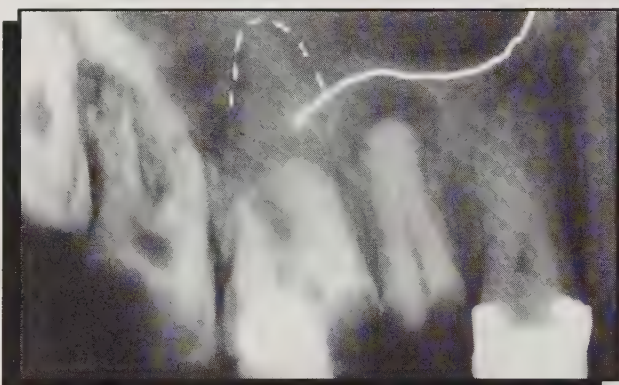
In this image, the antral floor was outlined freehand by the operator, using a digitizing tablet, to show the loss of cortex secondary to the periapical infection at the buccal roots of tooth 26.
